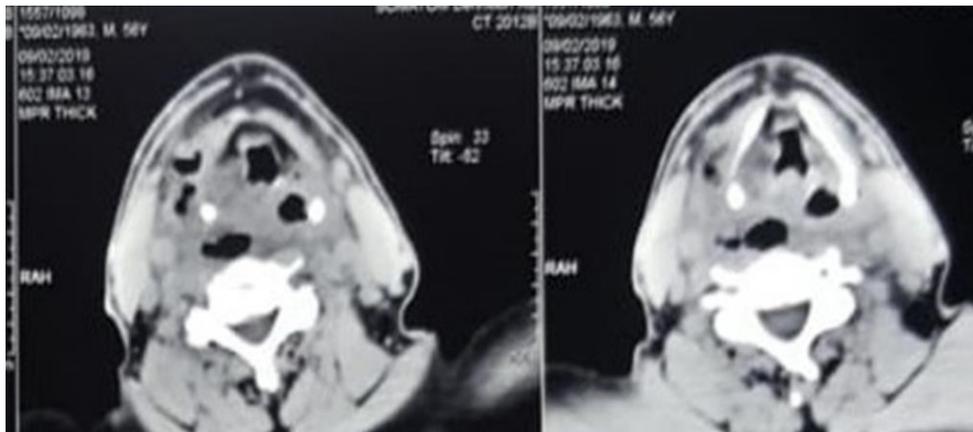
Axial sections of a cervical C + CT showing the sites of the collection
